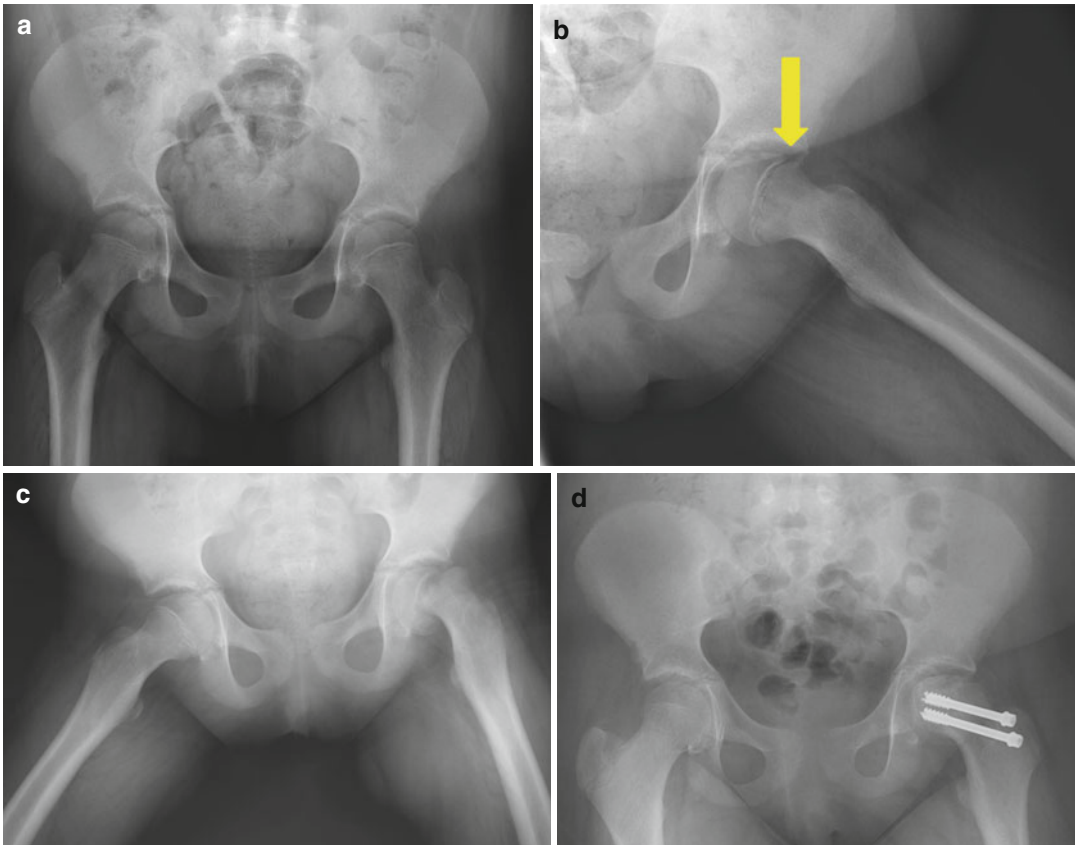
The need to diagnose SCFE is evident in this series of radiographs. An AP pelvis (a) and lateral left hip (b) radiograph in a 12-year-old girl with thigh and knee pain. Note the very subtle left SCFE (arrow). This was not
